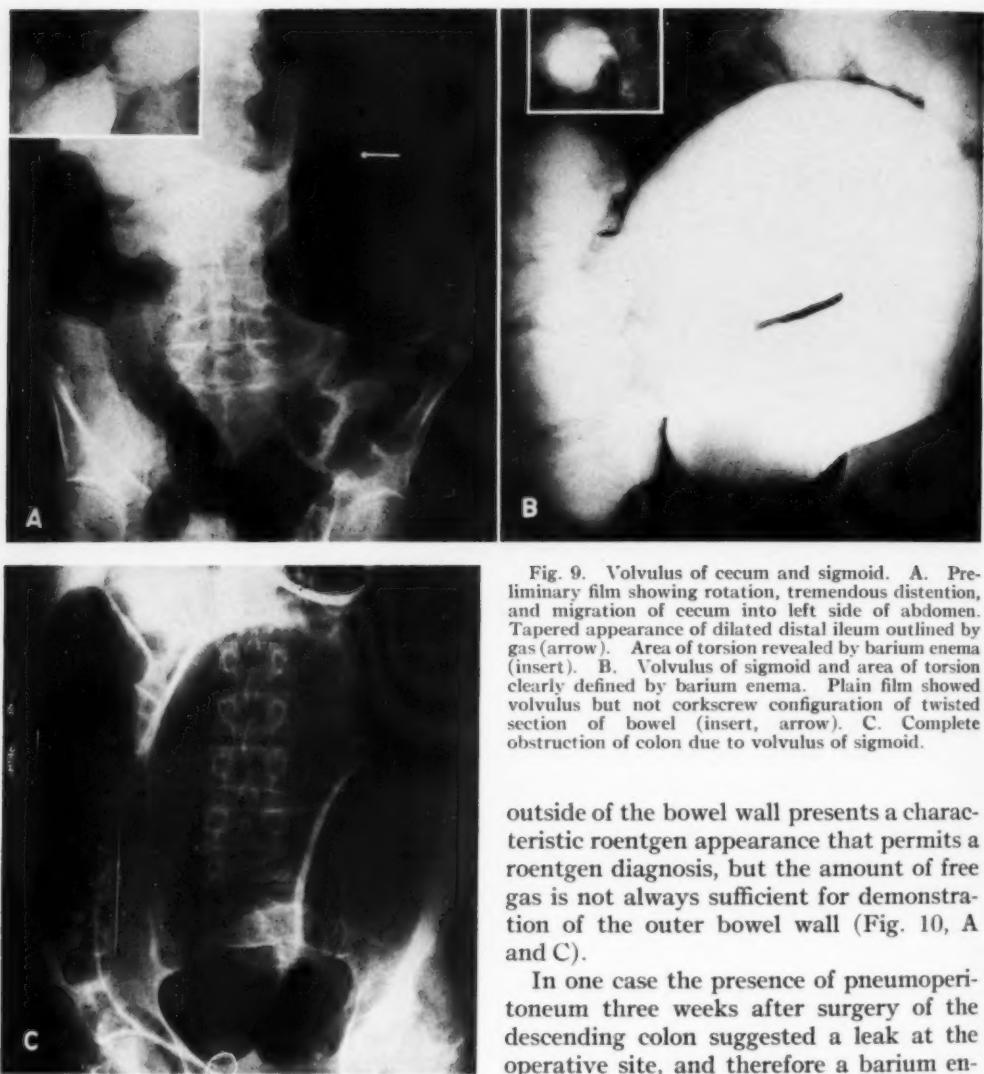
Volvulus of cecum and sigmoid. A. Preliminary film showing rotation, tremendous distention, and migration of cecum into left side of abdomen. Tapered appearance of dilated distal ileum outlined by gas (arrow). Area of torsion revealed by barium enema (insert). B. Volvulus of sigmoid and area of torsion clearly defined by barium enema. Plain film showed volvulus but not corkscrew configuration of twisted section of bowel (insert, arrow). C. Complete obstruction of colon due to volvulus of sigmoid.
